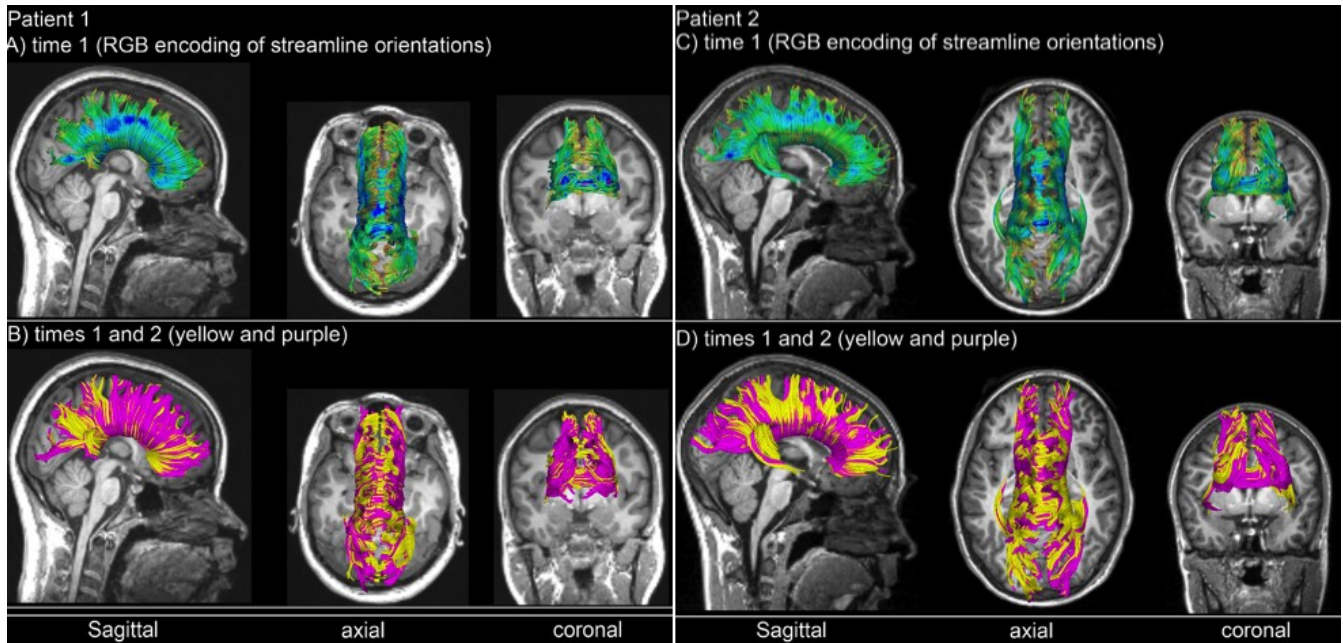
DTI-constrained reconstructions of the corpus callosum in two representative mTBI patients (Patient 1: A and B; Patient 2: C and D). Insets A and C depict RGB-encoded streamline orientations for the acute scan of each patient. Insets (B) and (D) help to visualize differences in WM streamline locations across time points. These may be due to pathology-related processes, to DWI/DTI artefacts or to other confounds.
